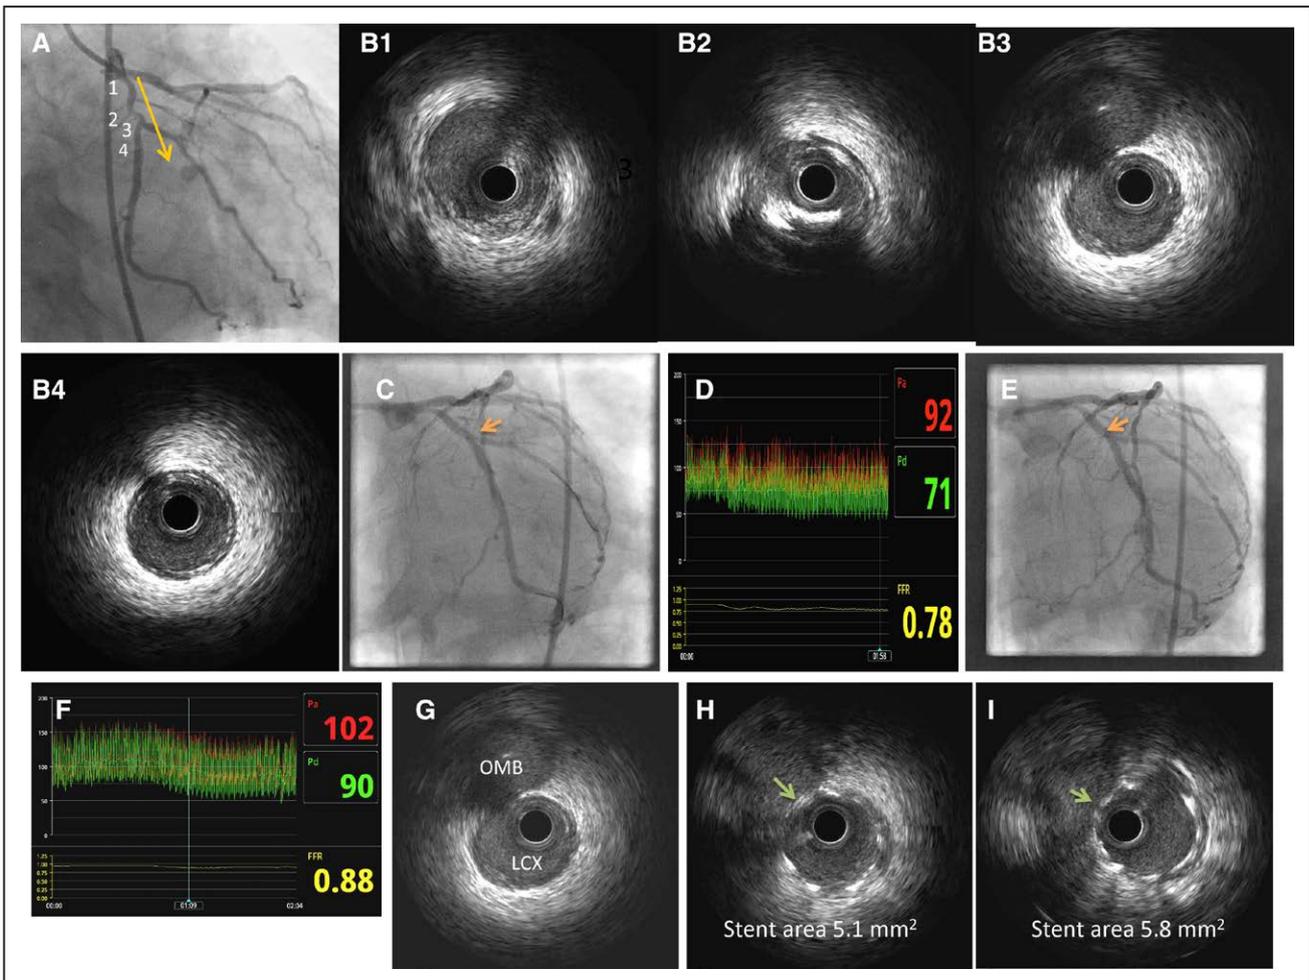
Images of intravascular ultrasound (IVUS), angiography, and fractional flow reserve (FFR) measurements from a study patient. A representative case of study patient in whom FFR of the obtuse marginal branch (OMB) was 0.78 after stenting of the left circumflex (LCX) coronary artery. After proximal optimization technique (POT), OMB FFR improved to 0.88. Therefore, SBD+final POT were not needed. A, Baseline coronary angiography shows a significant stenosis of the LCX and OMB; B1–B4 shows IVUS images of the proximal reference, stenosis frame, bifurcation frame, and distal reference, respectively. C and D, After deployment of a 3.0×23 DES to the LCX; the stenosis in the LCX significantly improved, but there was a 70% stenosis at the ostial OMB (arrow), and FFR of OMB was 0.78. E and F, After POT with a 3.5×8 mm balloon, the stenosis at the ostial OMB significantly improved, and FFR of OMB has now improved to 0.88. G, IVUS of bifurcation frame at baseline shows ostial OMB is patent. H, After the LCX stenting, the struts are covering ostial OMB (arrow). I, After POT, IVUS shows the struts are now separated (arrow), and stent area increased from 5.1 mm² after stenting to 5.8 mm² after POT. SBD indicates side-branch dilation.
